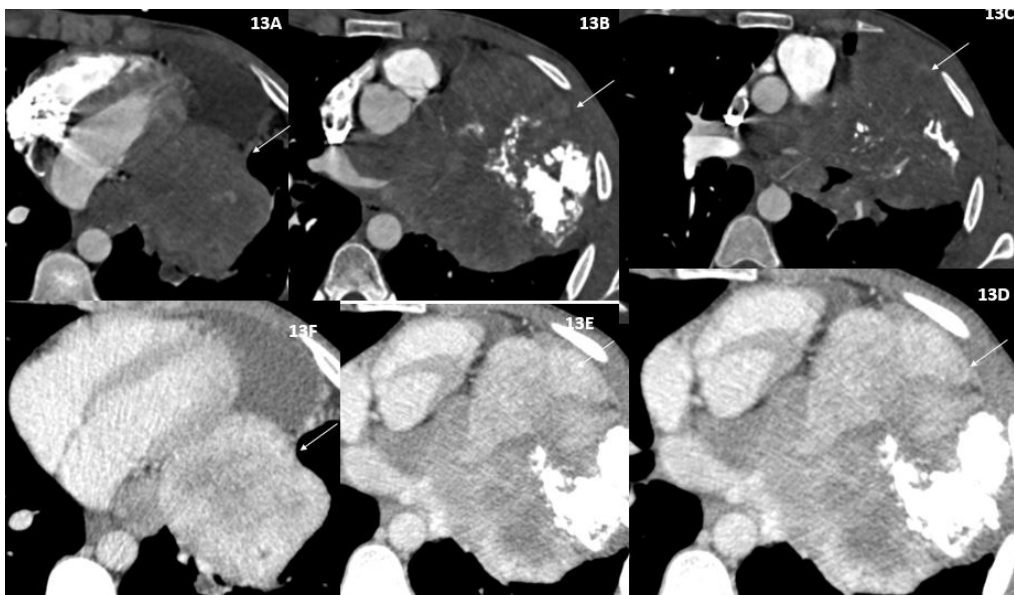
Case 3. A-C) 4-chamber arterial phase CT images show calcification within the mass in the left hemi-thorax and extension to the antero-lateral chest wall. D-F) 4-chamber arterial phase CT images show heterogenous post-contrast enhancement of the mass in left hemithorax
